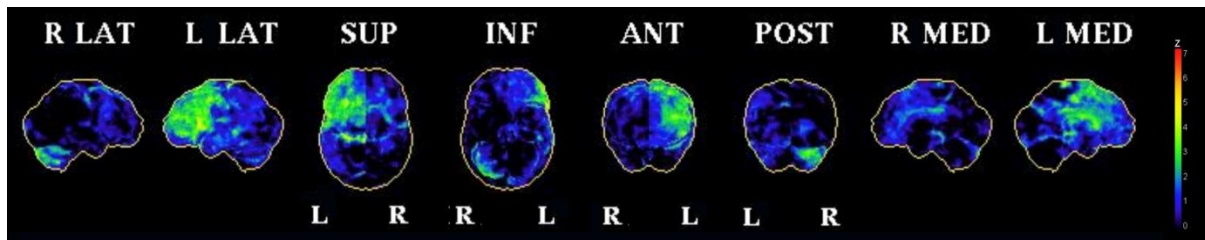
FDG-PET scan of VP at first time point showing significant hypometabolism (> 2 SD below normal) asymmetrically in L dorsolateral, medial and lateral orbital frontal regions including anterior cingulate cortex. Images are created from NeuroStat analysis with raw images subtracted from average of 25 healthy subjects' scans, and coloured based on standard deviation values (scale on R). Legend: L = left, R = right, LAT = lateral, SUP = superior, INF = inferior, ANT = anterior, POST = posterior, MED = medial.
